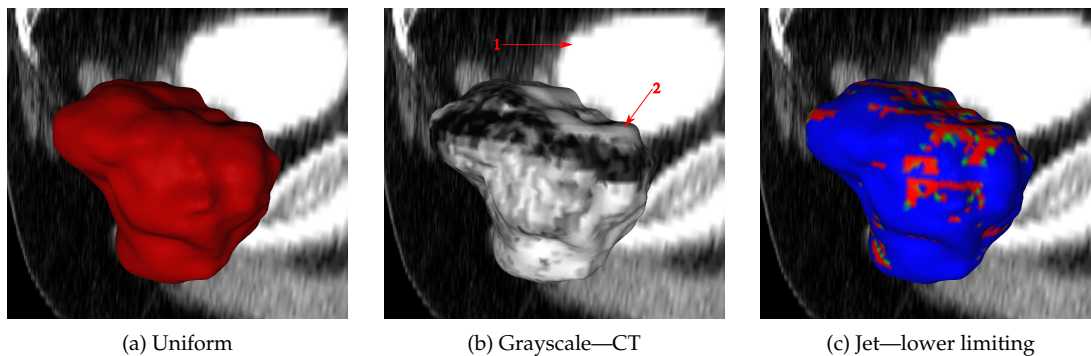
Isodose surface rendered with three colourmaps: uniform (a), grayscale (b), and jet (c). In the background, a sagittal CT slice is also rendered to give context to the scene. In (b), the CT values are mapped to shades of gray. Arrow (1) shows the location of the bladder on the CT slice; arrow (2) shows the bladder CT values mapped onto the dose surface. The planner can have an idea of the structures affected by that particular dose. In (c), red indicates lower limiting areas, in which the dose is close to the PTV lower bound. Notice that one may conclude, that some of these regions belong to the bladder, as they are depicted as such in (a). However, due to the fact that the PTV and the bladder overlap, these areas belong exclusively to the PTV during planning.
